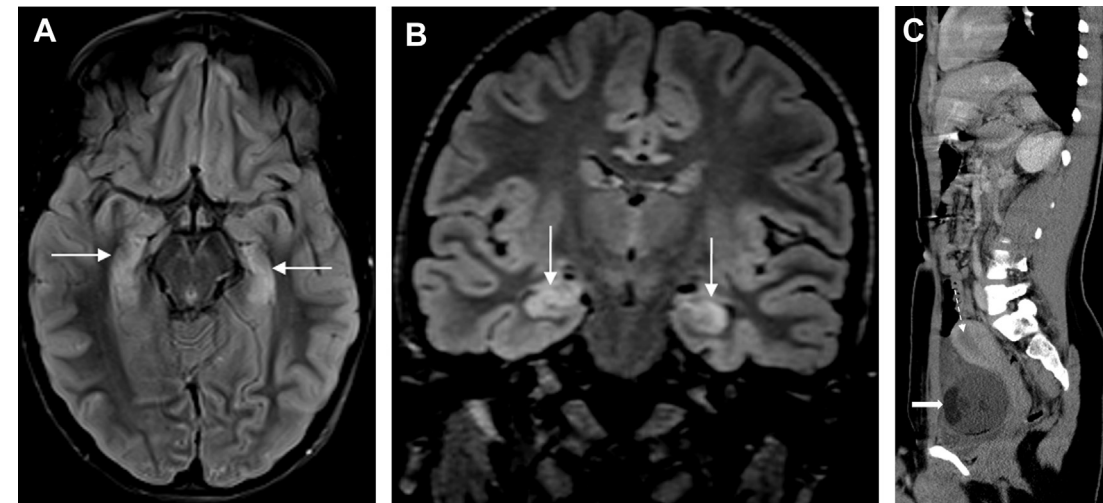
Limbic encephalitis in a 28-year-old woman with ovarian teratoma. Axial (A) and coronal (B) FLAIR images show bilateral hyperintensity and mild enlargement of the hippocampus proper (arrows). Sagittal reconstructed image through the pelvis shows an ovarian mass with a fat signal (arrow). Note normal stretched uterus (dash arrow) due to mass effect.
